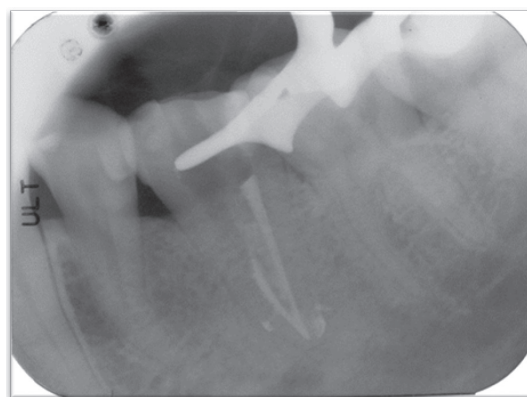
Radiographic image of mesial and distal root canals filled with gutta-percha and epoxy resin-based sealer using lateral compaction in a combination with warm vertical compaction (the hybrid technique). Post space was prepared in the mesial canal. Flowing of gutta-percha and/or sealer into the isthmus area between the two root canals was observed. Furthermore, the filled lateral canals and sealer extrusion were detected at the apical level.
